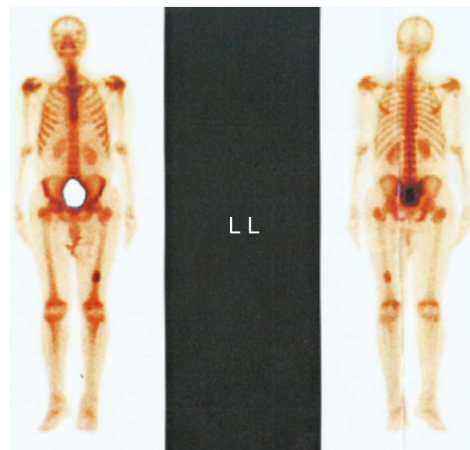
Whole body bone scan performed in an 81-year-old with prostate adenocarcinoma. Description of Figure 5: Whole body bone scan performed in an 81-year-old with prostate adenocarcinoma. There are focal hyperfixation in the distal diaphyseal of the left femur suggestive of solitary secondary bone localization (or osteosarcoma?). We therefore conclude that there is a scintigraphic aspect of solitary secondary left femoral bone localization, without ruling out osteosarcoma of the left femur.
